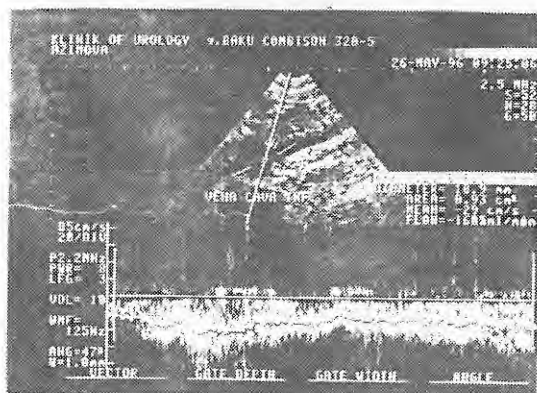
Spectrum shows the broader band of Doppler shift frequencies in a patient with chronic glomerulonephritis
